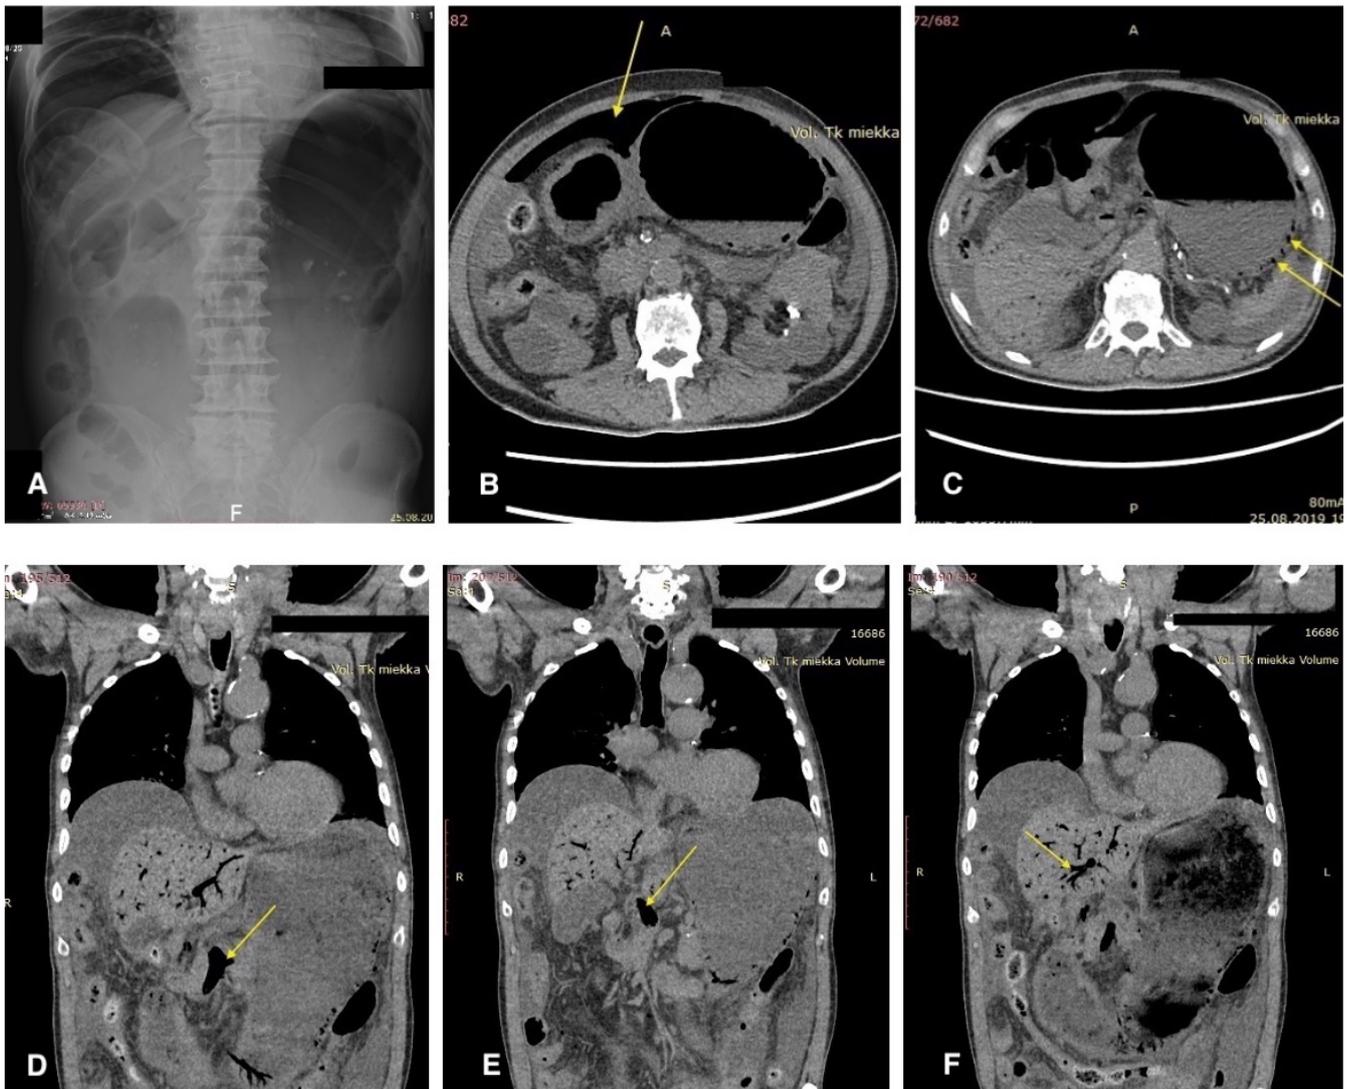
A: X-ray (AP) of the abdominal cavity on the standing. B: Abdomen axial CT. Free gas in the peritoneal cavity (arrow). C: Abdomen axial CT. Gas in the wall of the stomach (arrows). D: Abdomen coronal CT. Gas in the SMV (arrow). E: Abdomen coronal CT. Gas in the HPV (arrow). F: Abdomen coronal CT. Gas in the branches of the HPV (arrow).
